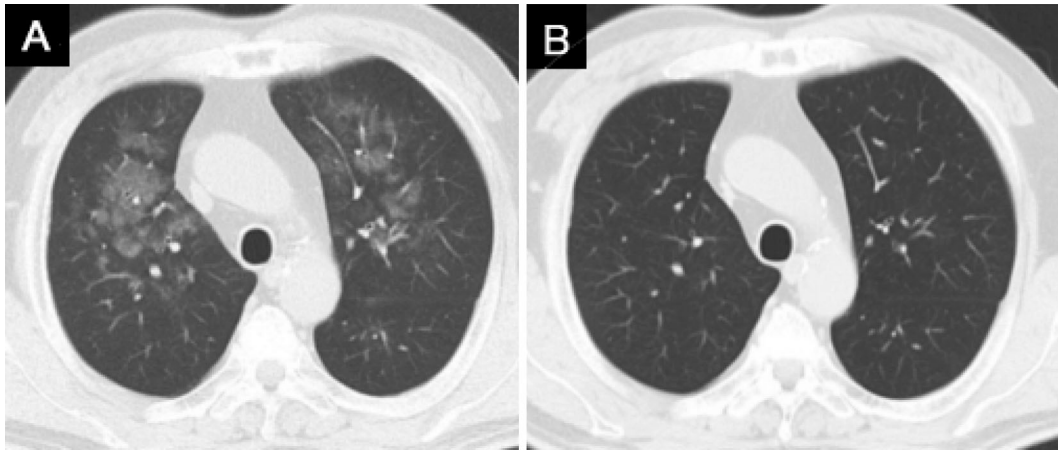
Chest computed tomography on admission (A) showed the presence of bilateral ground-glass opacity in the upper lung, which disappeared by day 12 (B).
